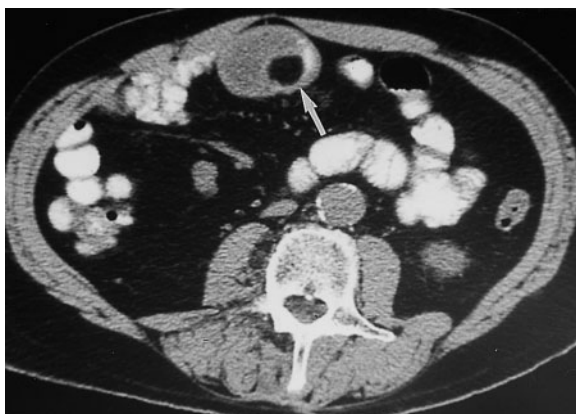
Small bowel intussusception caused by a lipoma as a lead point (same patient as Figure 1). CT at the level of the midabdomen shows a round hypodense mass, measuring 1.5 cm, in the tip of the intussusception surrounded by contrast medium (arrow). The fat density is homogeneous, characteristic of a lipoma. Ileoileal intussusception was confirmed at surgery.
